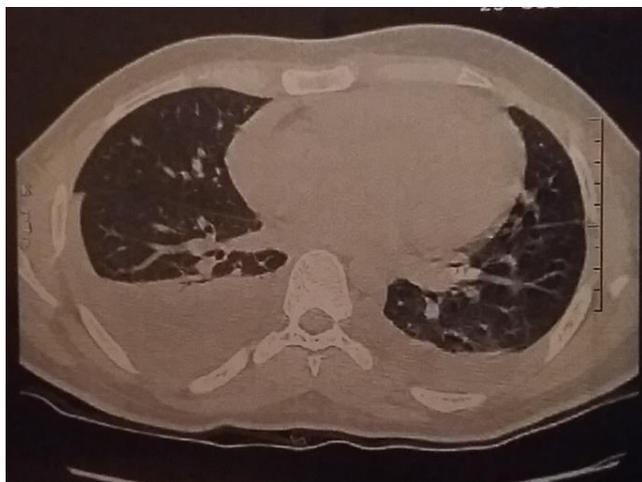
A CT scan of the thorax revealed findings of interstitial lung disease, bilateral pleural effusion of medium abundance and some Mediastinal adenopathy's.
